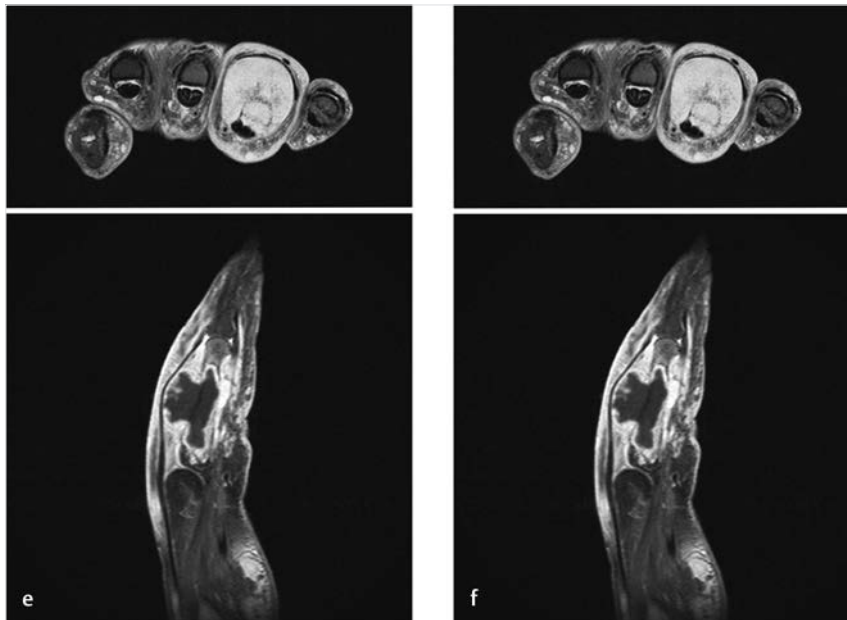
(Continued) (e, f) Preoperative MRI of the involved area.
